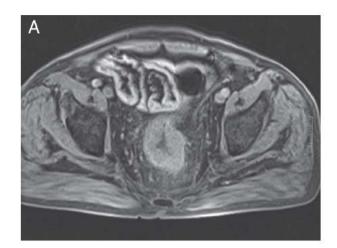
(A) High definition axial T1-weighted MRI post-gadolineum clearly depicts rectal tumour with transmural stranding in mesorectal fat. Reproduced from *Cravo M, Rodrigues T, Ourô S et al. Management of rectal cancer. Times are changing. GE Port J Gastroenterol. 2014*
